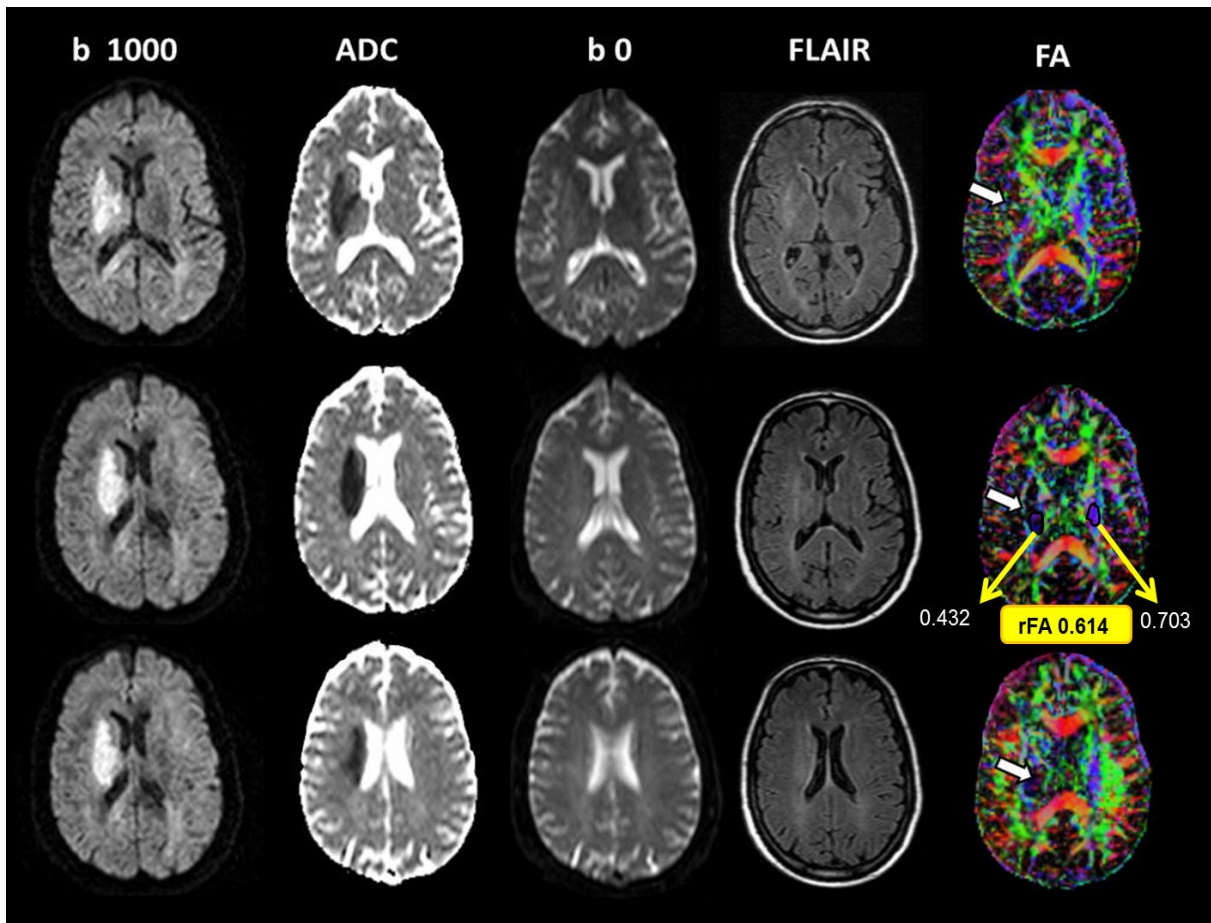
DWI, FLAIR and FA imaging in acute ischemic stroke > 4.5 h of onset (680 min) involving the right deep MCA territory. Markedly decreased FA was observed in the PLIC and right corona radiata. This is an example of how decreased FA predicts the stroke onset better than T2/FLAIR images, in which marked signal increase would have been expected (11 h of onset).
